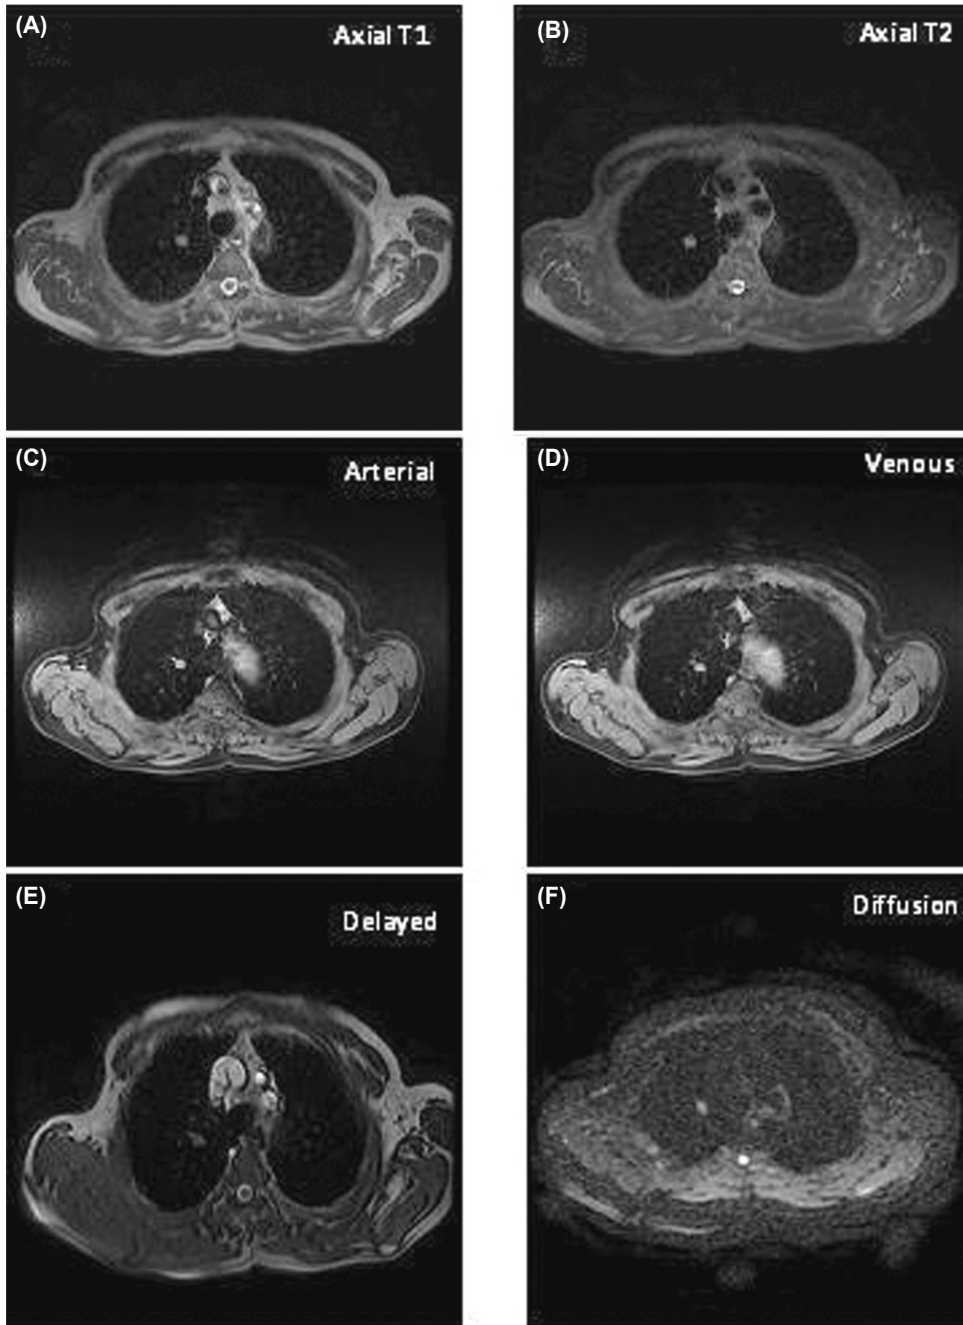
A 70-year-old male and a known case of metastatic cancer prostate. His X-ray was unremarkable, and his MRI confirmed right upper lung lobe solitary pulmonary nodule with spiculated margin, which measured 1.5 X 1cm and displayed isointense signal intensity at T1WI (A) & T2WI (B) in addition to pretracheal LN measured 1 cm. After dynamic post contrast phases that lasts for 4 minutes, the nodule showed homogenous enhancement at arterial phase (C) and washout at delayed phases (D, E). The ADC value was $0.9 \times 10^{-3} \text{ mm}^2/\text{s}$ with restricted diffusion (F) (nodule is bright), and the time-enhancement curve was of type A (G).
